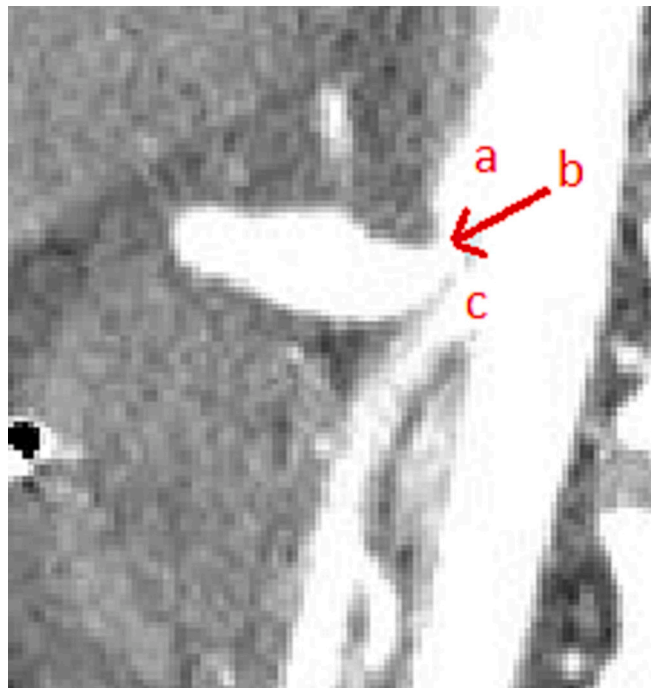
CT-angiography in sagittal plane revealing the origins of the celiac trunk (a) and the superior mesenteric artery (c). The arrow “b” points to the significant deformation of the celiac trunk which is consistent with the median arcuate ligament syndrome.
